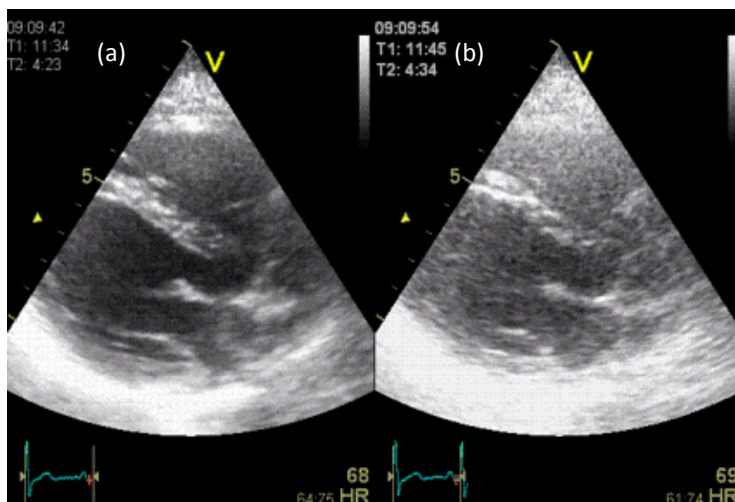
Parasternal long axis view of a heart: (a) harmonic-mode image and (b) fundamental B-mode image. Reproduced with permission from <http://folk.ntnu.no/stoylen/strainrate>.
